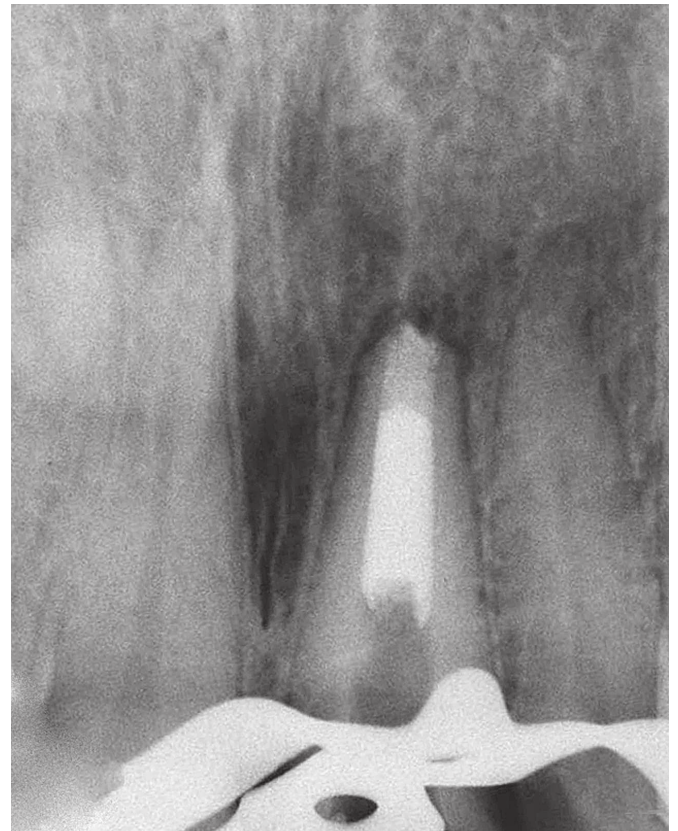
Periapical radiograph with MTA apical plug and thermoplastic filling.
